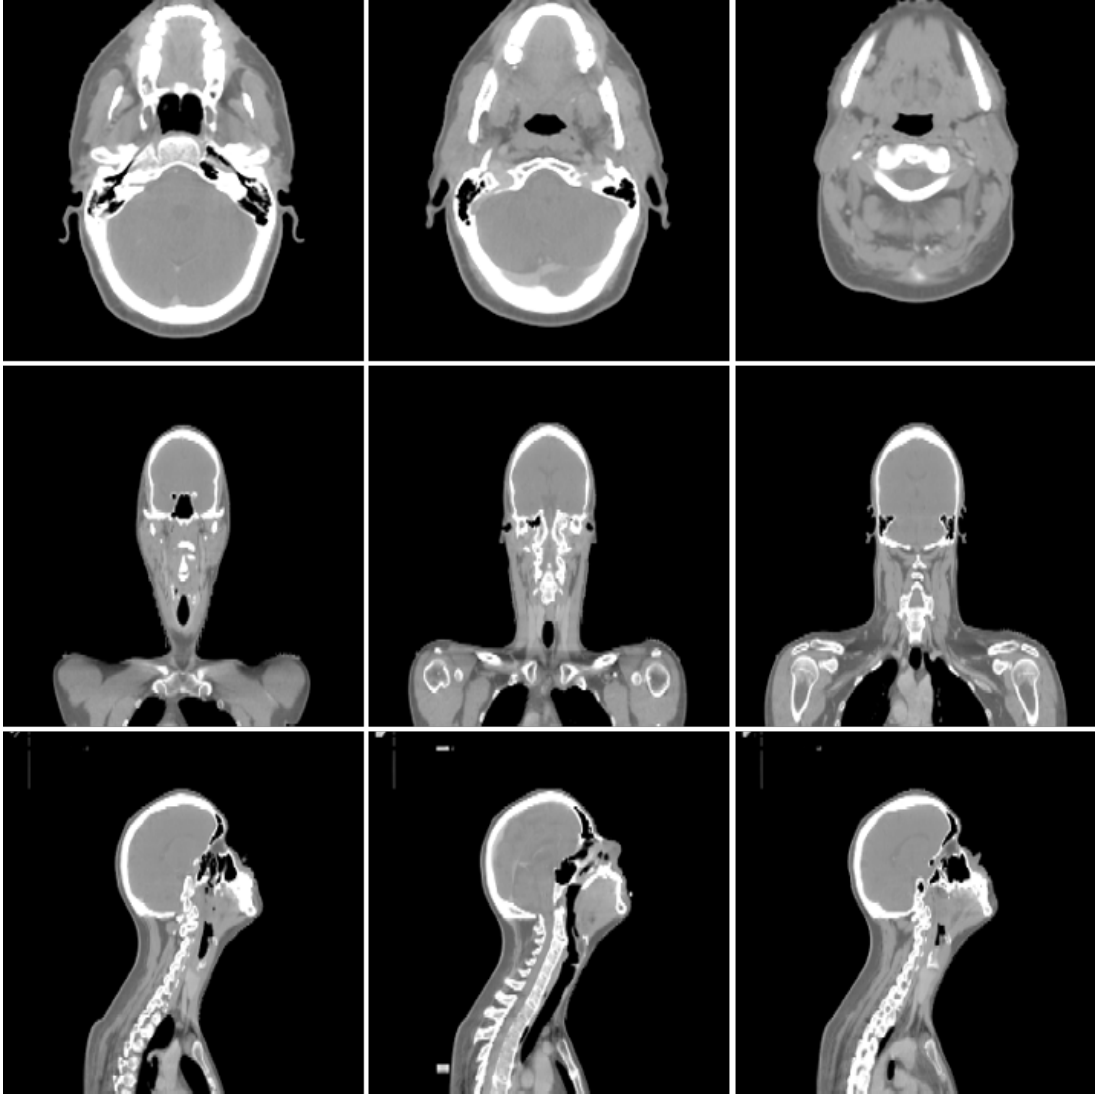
Some examples of the employed images in my database. The top row corresponds to CT images in the axial section, while the second and bottom row are CT images from coronal and sagittal section, respectively.
